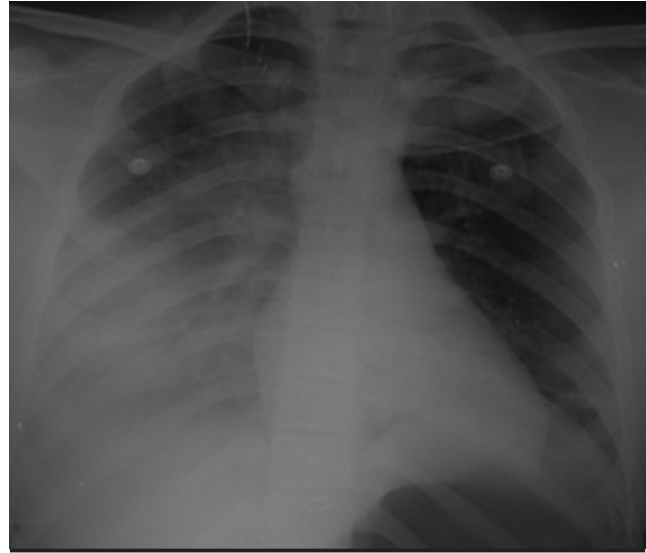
Chest X-ray at the time of the patient's presentation
